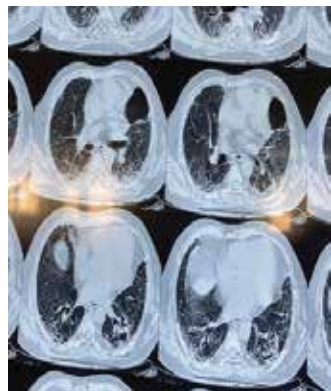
CT chest showing pneumothorax in left hemithorax with bilateral diffuse ground-glass opacities
